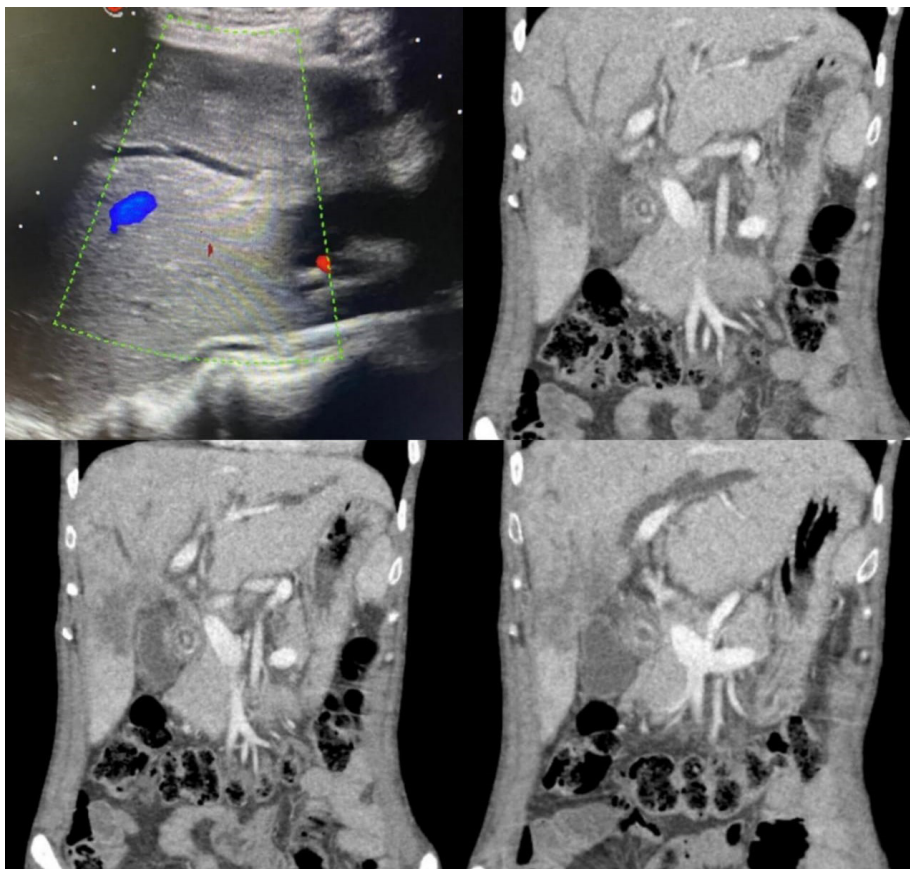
Top left image is an axial ultrasound image showing abrupt cut off in intrahepatic biliary channel in segment VIII of liver with retrograde distension of the biliary duct. Post contrast CT coronal images shows an ill-defined hypo enhancing infiltrating lesion in the right lobe of liver with no confluence of the right and left hepatic duct seen and abrupt cut off in biliary channels seen with their retrograde distention. Patient was diagnosed as perihilar cholangiocarcinoma infiltrating in the adjacent liver. Note was also made of the gall bladder neck calculus, however no extrinsic compression depicted.
